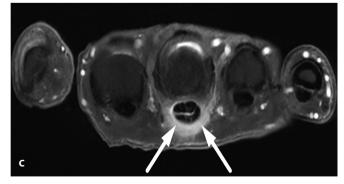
Synovioentheseal complex inflammation in chronic overuse, degenerative, and traumatic injuries. (a) Sagittal fat-saturated proton density-weighted magnetic resonance image (MRI) of a 12-year-old boy with Osgood-Schlatter disease, which is an overuse injury, reveals distal patellar tendon enthesopathy characterized by intra- and peritendinous hyperintensity, subcortical bone marrow edema at the entheseal insertion, and deep infrapatellar bursitis. (b) Sagittal fat-saturated T2W MRI of a 54-year-old woman with Haglund syndrome shows Achilles tendon enthesopathy characterized by intra- and peritendinous hyperintensity, subcortical bone marrow edema, and erosion at the entheseal insertion, and retrocalcaneal bursitis with Haglund deformity of the calcaneus. (c) Transverse fat-saturated T1W post-contrast MR image of a 44-year-old man with a 1-month history of pain following an episode of lifting luggage with a single finger shows traumatic A1 pulley enthesopathy (arrows) with mild flexor tenosynovitis.
